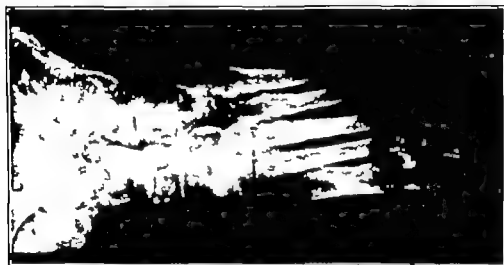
Rudeck's atrophy. X-ray taken three months after a minor injury to the foot showing marked atrophy of all the bones of the ankle and foot. There was superimposed soft tissue swelling. Treatment was sympathectomy and the use of parathormone and calcium by mouth.
